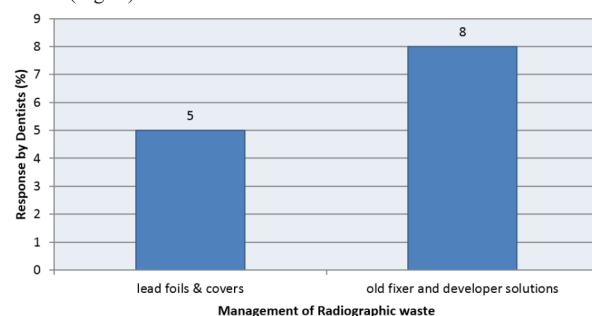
The minority of dentist's response about management of radiographic waste
